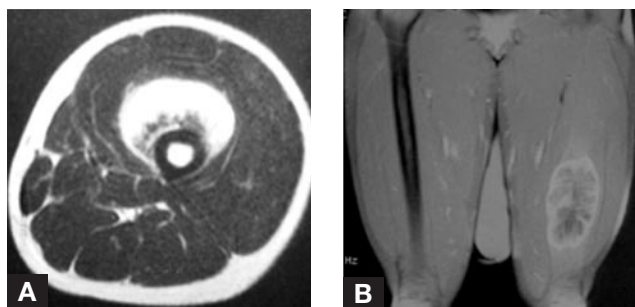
Left femur: (A) magnetic resonance imaging (MRI) axial scan (T_2 -weighted contrast-enhanced) demonstrating soft-tissue enhancement and (B) MRI coronal scan (T_1 -weighted) showing the extent of the lesion.
